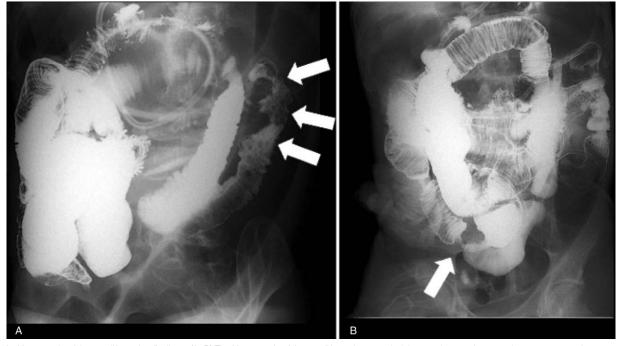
X-ray study of the small intestine findings. (A, B) The X-ray study of the small intestine revealed that an abnormal mucosal pattern suggesting narrowing of the internal organs is observed at left flank and right lower abdomen (arrows).
